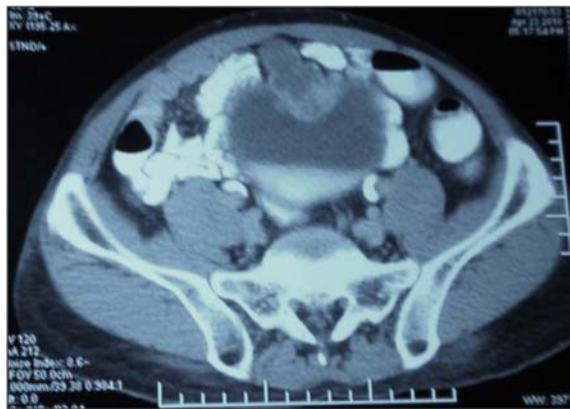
CT scan whole abdomen showing infiltrative mass at anterior wall and dome of bladder, size 4x4.6x 3.5 cm. No evidence of pelvic lymphadenectomy or distant metastatic disease was found.
